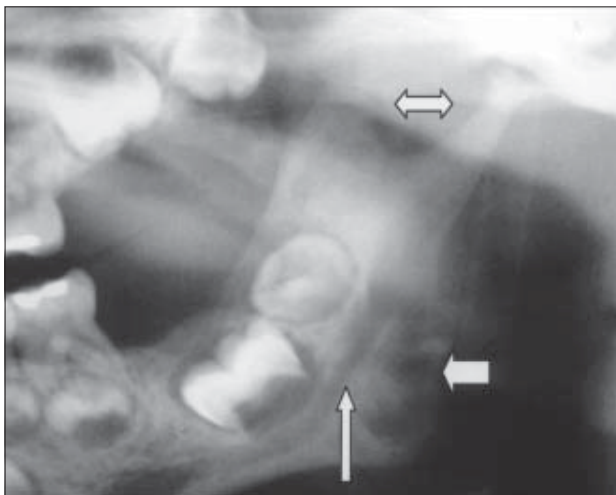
Cropped panoramic radiograph of case 4 showing multilocular radiolucency in the angle of the mandible (thick arrow), mandibular canal enlargement (long arrow), and condylar and coronoid hypoplasia (double arrow)
